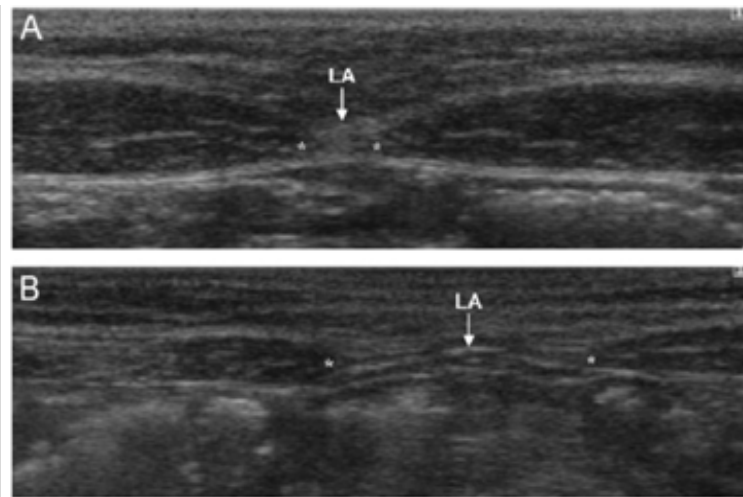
Ultrasound measurement of the IRD: the 3 locations recommended
